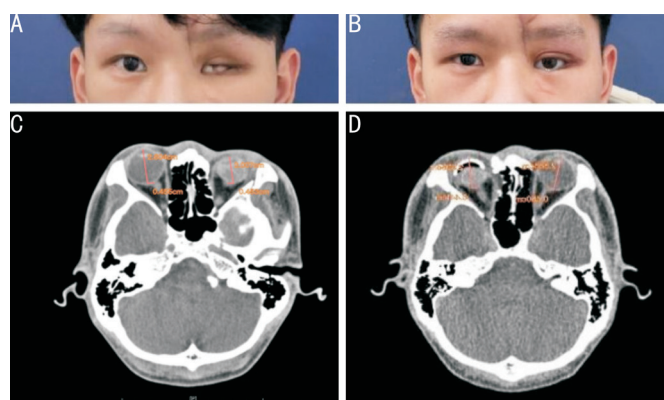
Vitreous cavity implanted into FCVB after severe ocular trauma in the left eye in October 2022 A, C: In January 2023, during the follow-up examination, there was eyeball atrophy accompanied by upper eyelid ptosis and significant eye misalignment. The axial length of the eye was 20.07 mm, which was significantly atrophied compared to the opposite eye. The height of the eyelid fissure was 5 mm, and the degree of eyeball protrusion was 5 mm; B, D: After wearing the artificial eye patch in March 2023, the appearance was significant improved with axial length of 23.06 mm, eyelid crack height of 9 mm, eyeball protrusion of 9 mm, and orbital CT showing partial gap between the prosthetic eye film and the eyeball. FCVB: Foldable capsular vitreous body; CT: Computerized tomography.
